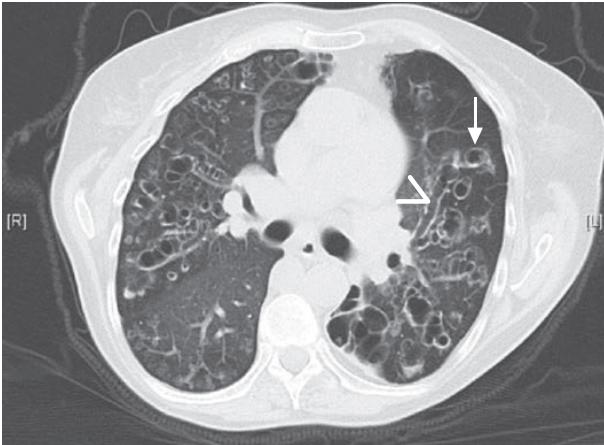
Representative chest CT image of severe bronchiectasis. This patient's CT demonstrates many severely dilated airways, seen both longitudinally (arrowhead) and in cross-section (arrow).
